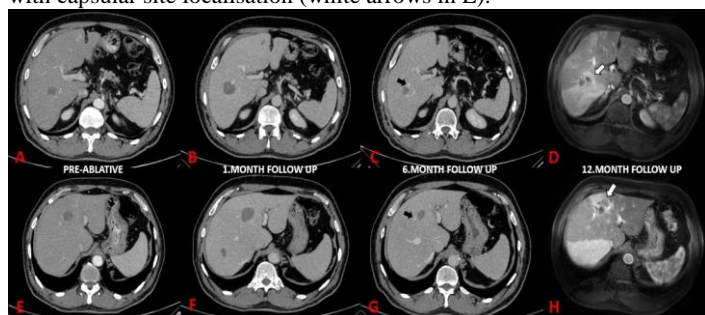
53-years-old male patient with liver metastases of colon cancer. Pre and post-ablative computed tomography (CT) and magnetic resonance (MR) images of two metastatic lesions located in segment 6 (A-D) and segment 4A (E-H). There was no evidence of local recurrence (LR) for both lesions in 1st and 6th months follow-ups. In addition to this, the CT images showed the volume reduction of two lesions. But, control contrast-enhanced liver MR images at the time of 12th month follow-up showed the crescentic shaped LR on noncapsular site for the lesion in segment 6 (white arrow in D) and crescentic shaped LR on capsular site for the lesion in segment 4A (white arrow in H). Note that, while the LR in segment 6 developed from the site of vascular proximity (black arrow in C), the LR in segment 4A developed from the other site of the adjacent vascular structure (black arrow in G).
